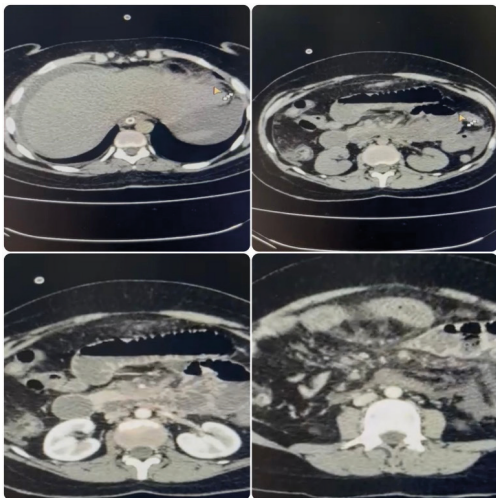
Axial sections of the computed tomography scan performed with and without venous contrast.
